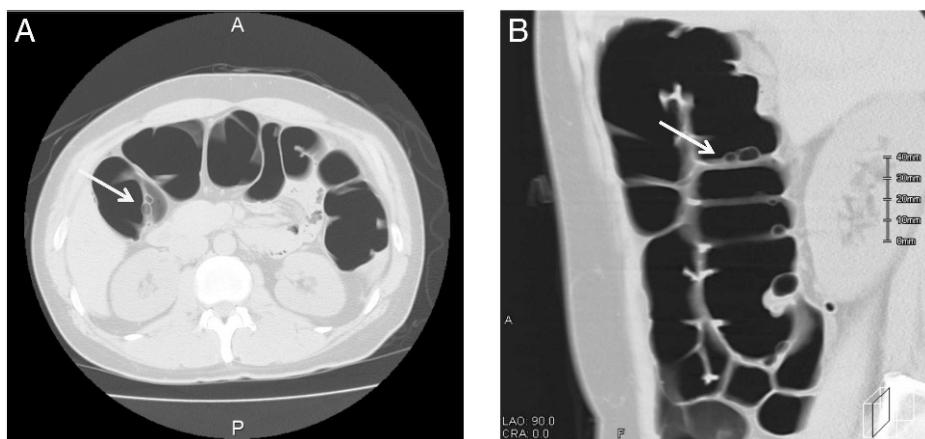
Air CT. (A) Multiple pneumatosis-like changes are observed along the transverse colon wall (arrow). (B) A longitudinal slice. Pneumatosis-like changes are observed at the same site.
